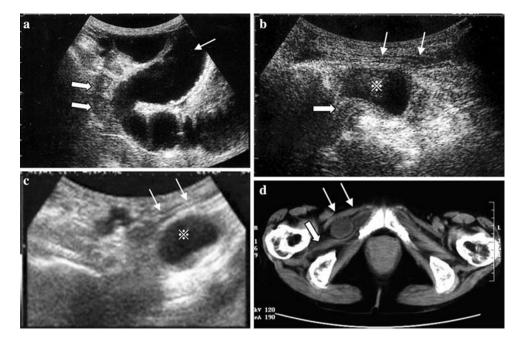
Ultrasonograms of the Case 2. a Ultrasound showed the evidence of small bowel obstruction by showing fluid-filled dilated small bowel (*arrow*) proximal to collapsed distal bowel (*broad arrows*). b The herniated intestinal segment (X) was delineated posterior to the pectineus muscle (*arrows*), strangulated at the hernia
